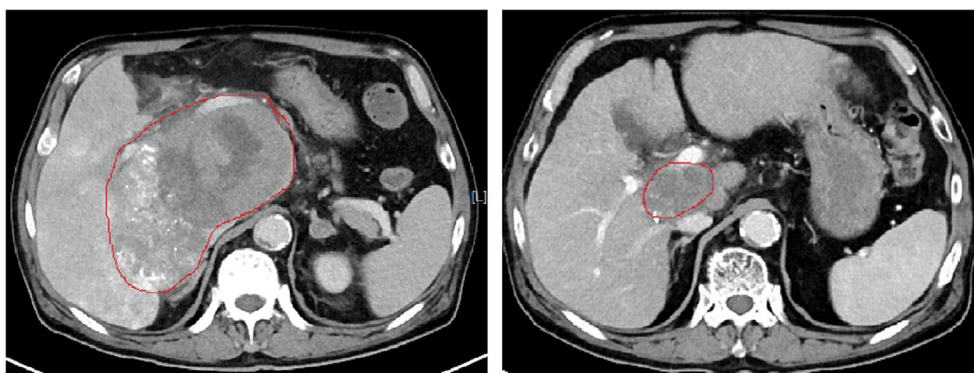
Change of the mass in CT after radiotherapy.
